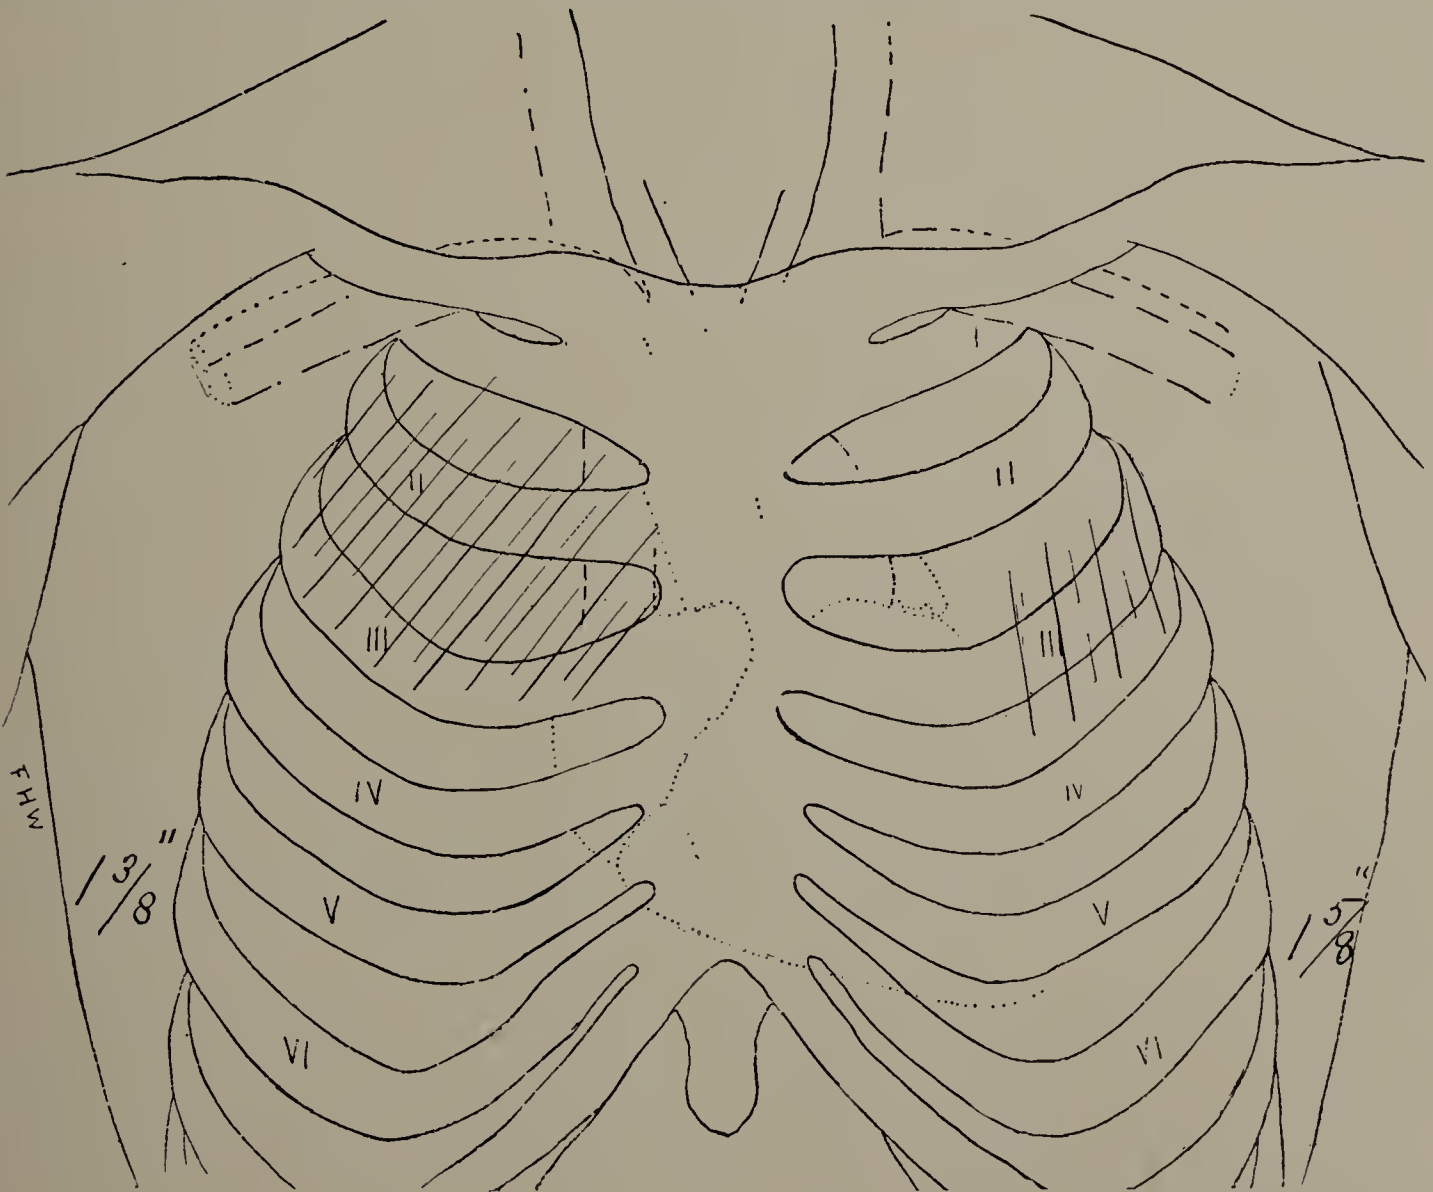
G. R. Fourth X-ray examination with screen. Signs by X-rays; shaded lungs and excursion of diaphragm restricted on both sides. No physical signs at this time. (One-third life size.)
